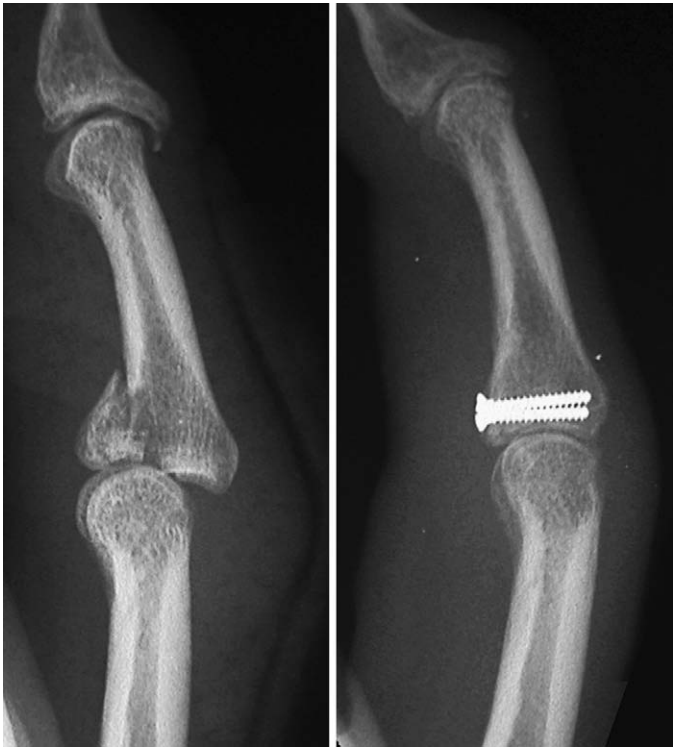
Pre- and postoperative radiographs of internal fixation of PIP fracture-dislocation using the volar approach.
